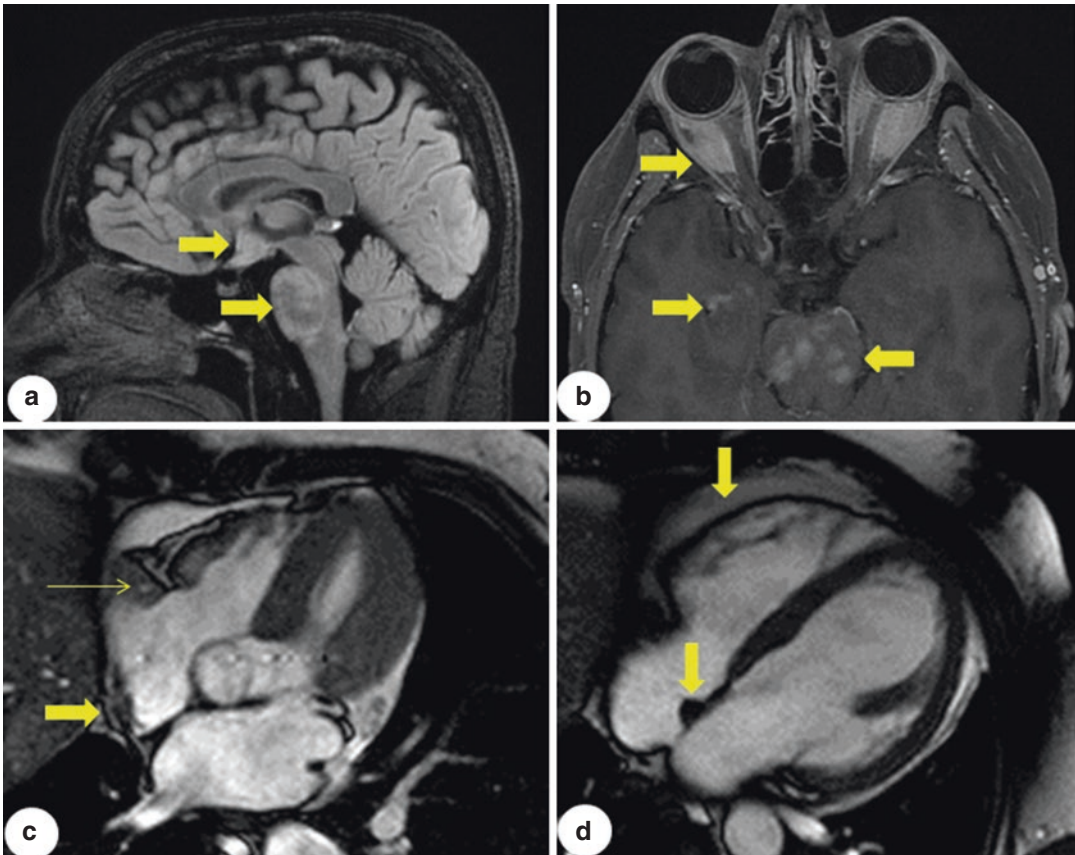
Brain and cardiac imaging findings in patients with Erdheim-Chester disease (ECD) and overlap Langerhans cell histiocytosis and ECD (LCH-ECD). (a, b) Central nervous system involvement in an ECD patient: (a) brain MRI (sagittal) showing pathologic and increased gadolinium uptake in the hypothalamus (upper arrow) and pons (lower arrow). (b) Brain MRI (axial): irregularly increased intensity in the pons (right-hand arrow), parahippocampal region (lower left-hand arrow) and retro-orbital space (upper left-hand arrow), where the pathologic
